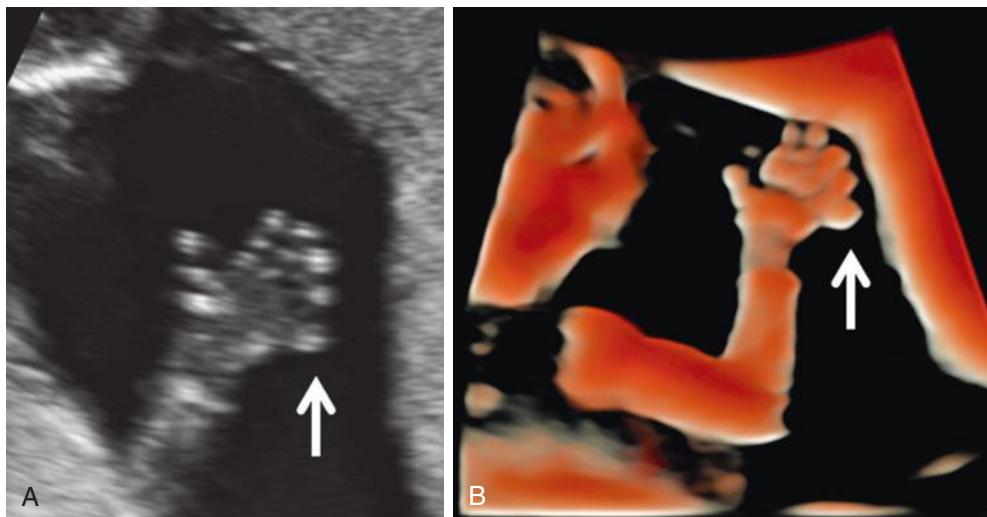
Two-dimensional (A) and three-dimensional (B) ultrasound-rendered volume using HDlive mode showing postaxial polydactyly (arrow).
